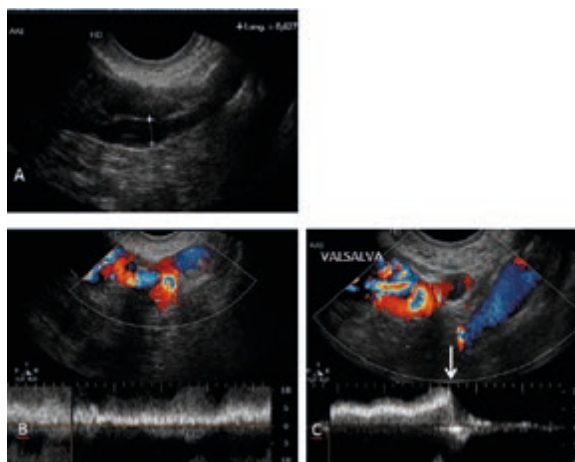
A) TV ultrasound showing the dilated left gonadal vein distal sector. B) Spectral Doppler assessment showing a continuous increased flow at rest. C) After the Valsalva maneuver (white arrow) the flow decreases significantly until it becomes interrupted, a finding that is highly indicative of derivative flow due to NCS-type proximal vascular compression.
